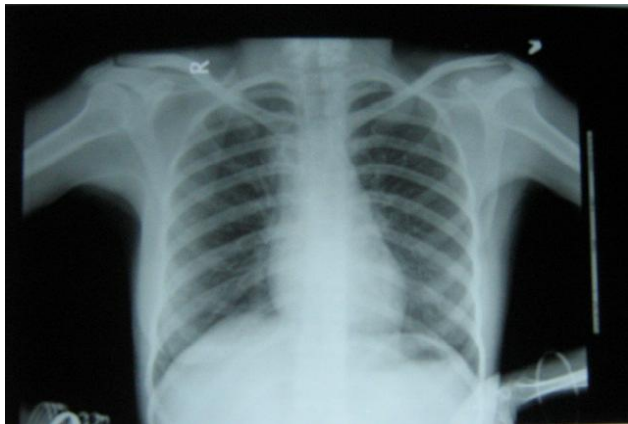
Chest X-ray showing no abnormalities.
